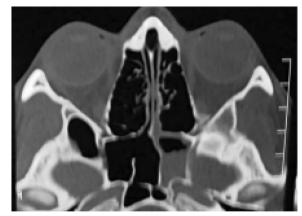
Case 6. Left sphenoid sinusitis. CT scan axial view showing partial filling of the left sphenoid sinus without bone destruction or bone thickening
